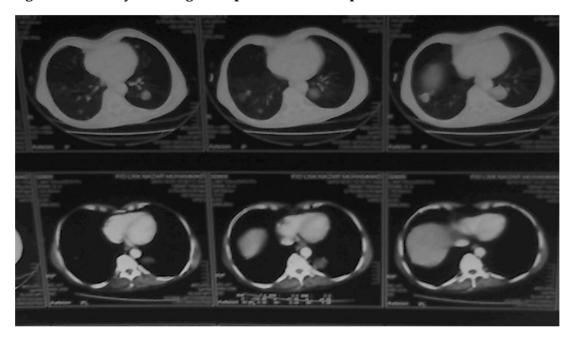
CT scan showing nodules in the lungs.
